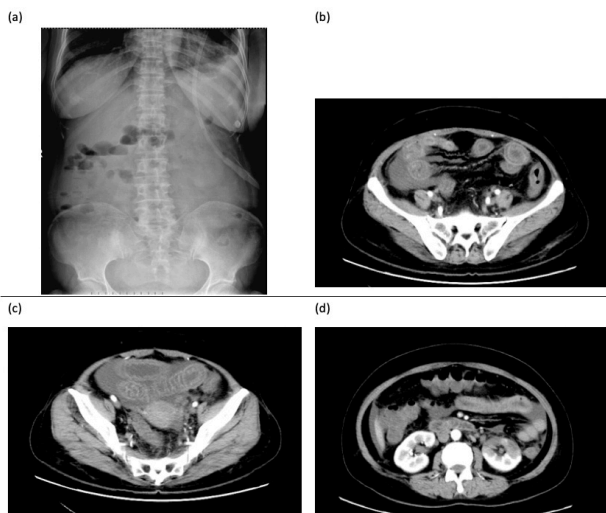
Plain radiograph showed dilated loops of small bowel with multiple air-fluid levels. (b,c,d) abdominal enhanced CT revealed intestinal vascular loop-like enhancement, intestinal dilatation indicating ileus, effusion in thoracic cavity, abdominal cavity and pelvic cavity.
